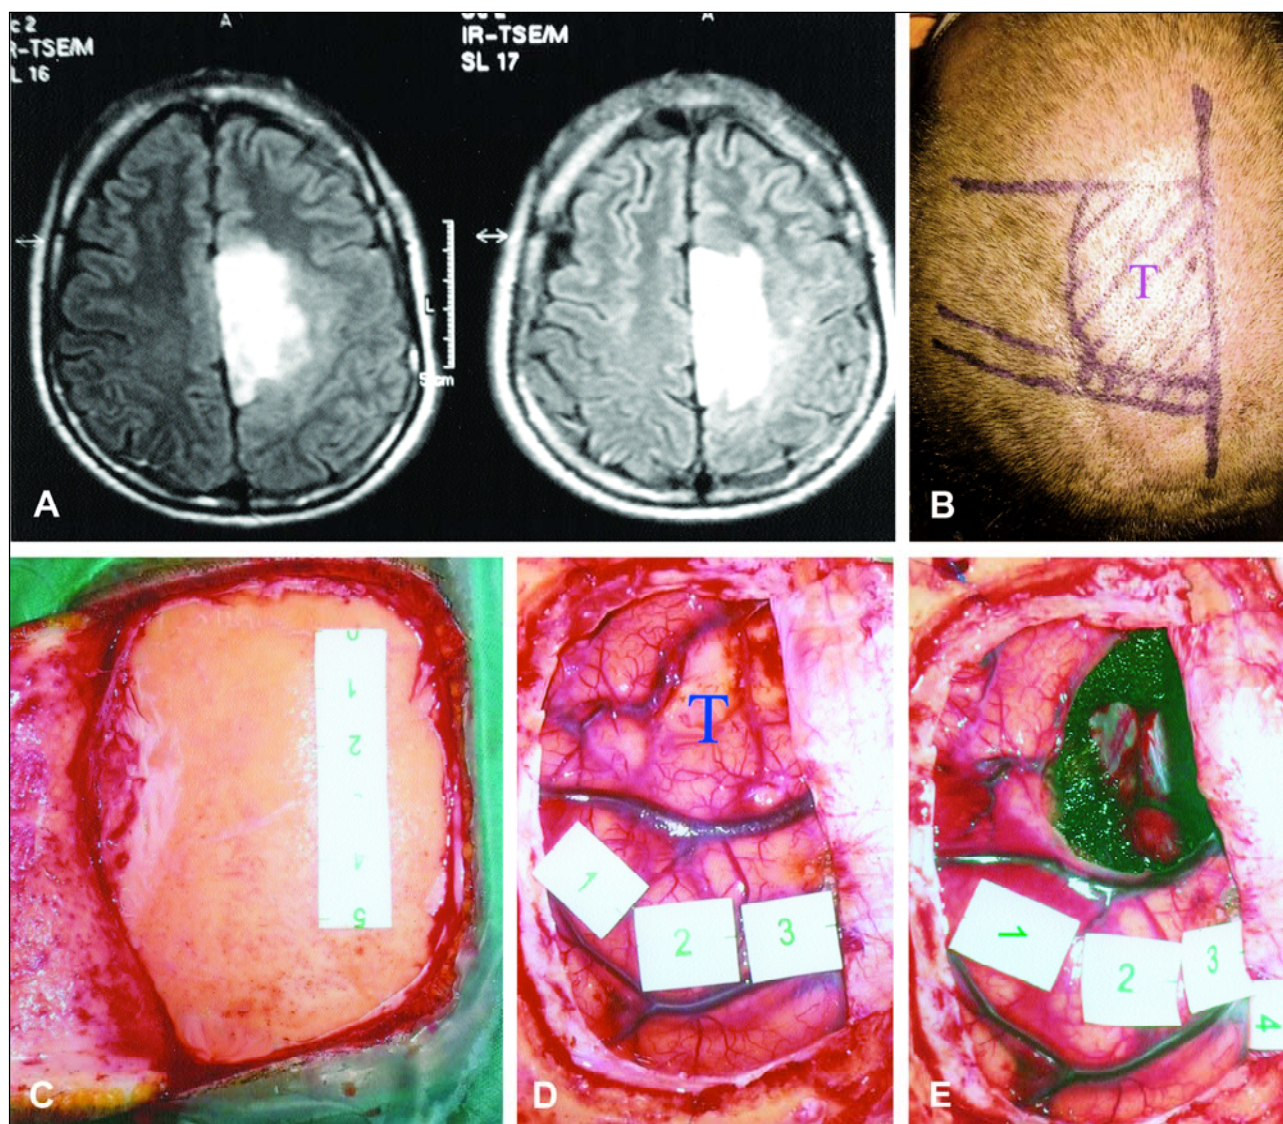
Astrocitoma grade III in the left superior frontal gyrus displacing the motor cortex in a 38 years old patient. (A) pre-operative axial MRI. (B) markings on the scalp estimate the location of the tumor (T), planned surgical incision, and pre-central gyrus based on MRI data. (C) the coronal suture is identified and about 5 cm behind it the central sulcus begins. The craniotomy site was planned. (D) after duramater opening the brain surface was exposed and the cortical stimulation begun: movements on the right hand (point 1) and movements on the right arm (point 2 and 3) could be elicited. The location of the tumor (T) was confirmed. (E) localization of the motor function on the right leg and foot (point 4) and complete resection of the lesion with preservation of motor function was performed.
